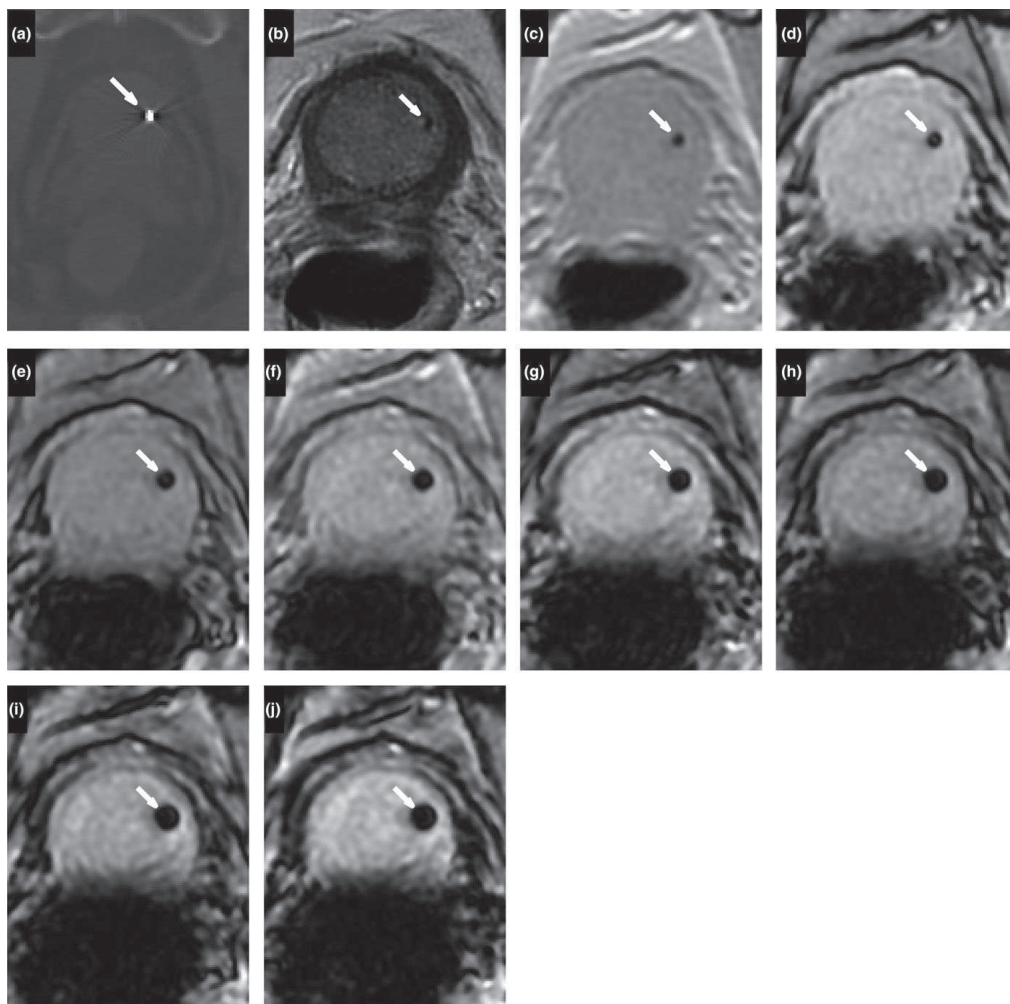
Visualization of a gold fiducial marker (GFM) with different TEs. Figure shows GFM (bold arrow) in (a) CT, (b) MRI T2w PROPELLER, (c–j) MRI MEGRE for increasing TE in the span 2.38–23.6 ms with an inter echo time of 3.03 ms. The shape of the signal void from the GFM is round and the area is increasing with increasing TE. The images (c–j) visualize also the dependence of increasing echo time to the artifact below the prostate, originating from rectal gas.
